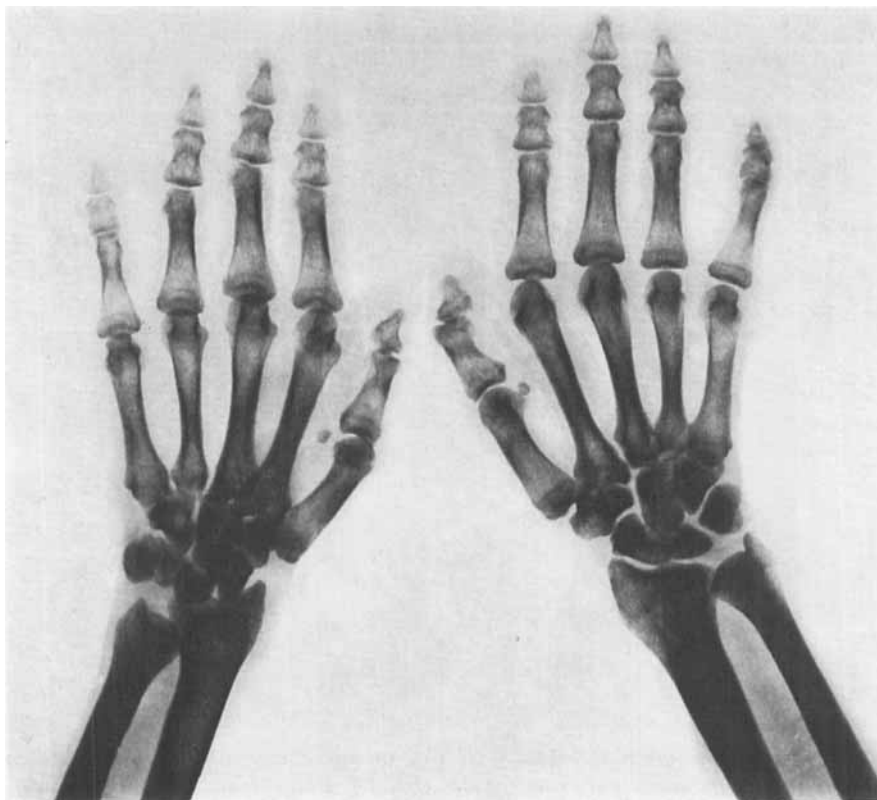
Roentgenogram of hands. Case 1. The terminal phalanges were short and tapered. The middle phalanges were short and wide. The metaphyseal part of the metacarpals and the proximal phalanges were abnormally broad. Over-growth of left radius was noted.
